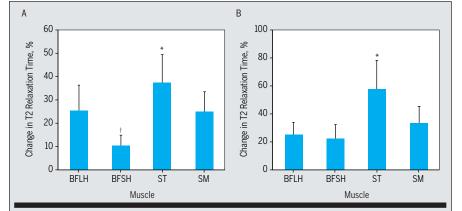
Percentage change in functional magnetic resonance imaging T2 relaxation times of each knee flexor muscle following (A) the 45° hip extension exercise and (B) the Nordic hamstring exercise. Values are displayed as the mean percentage change compared to values at rest. In (A): *Significantly different from BFSH (P<.001). †Significantly different from BFLH (P<.001) and SM (P = .001). In (B): *Significantly different from BFSH (P<.001) and BFLH (P = .001). Values are mean \pm 95% confidence interval. Abbreviations: BFLH, biceps femoris long head; BFSH, biceps femoris short head; SM, semimembranosus; ST, semitendinosus.
